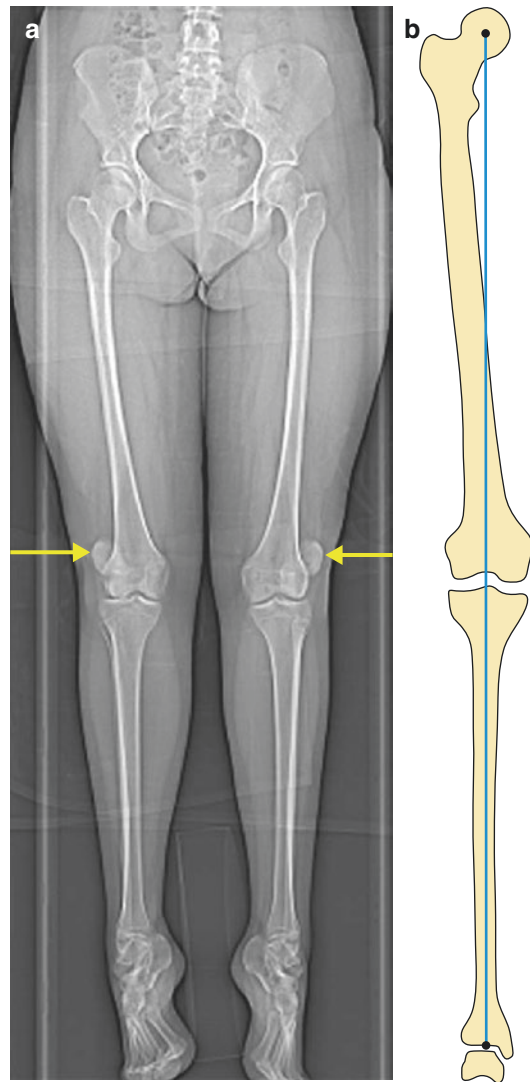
(a) It is important to ensure that the patella and the tibial tuberosity are facing anteriorly before measurements relating to alignment are carried out. If the patella is rotated, as shown in this CT scanogram, then the measurements obtained will be unreliable. (b) Normal mechanical axis of the lower limb
